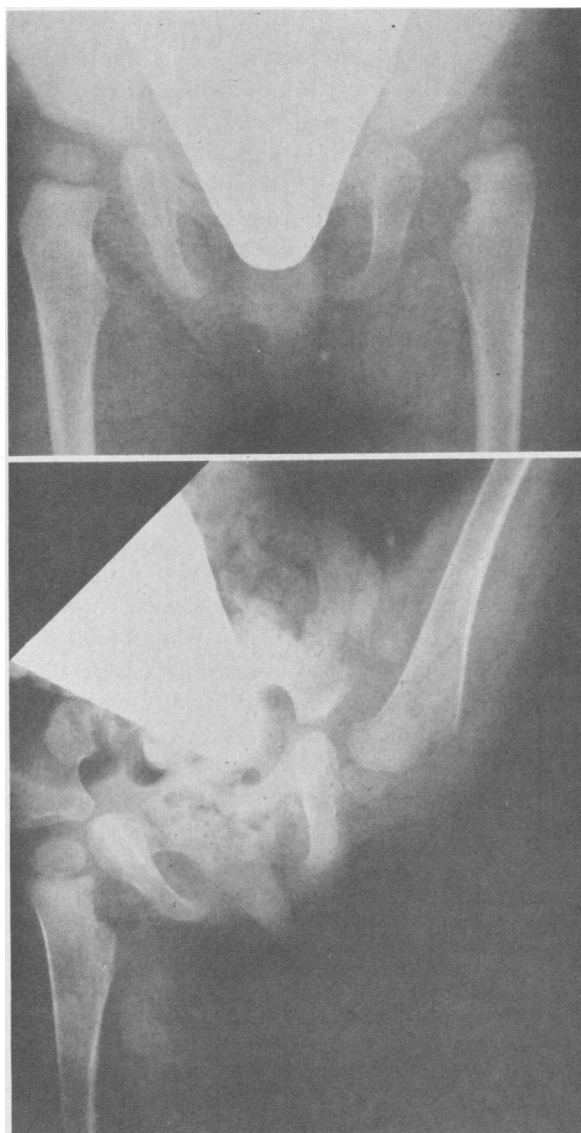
Diagnosis of congenital dislocation of the left hip delayed to age 17 months. A, Roentgenogram at beginning of treatment. Relocation was obtained after ten days of traction. Containment was subsequently attempted with frog-leg spica cast. B, Roentgenogram at end of treatment shows that the frog-leg position resulted in inferior and anterior dislocation.
